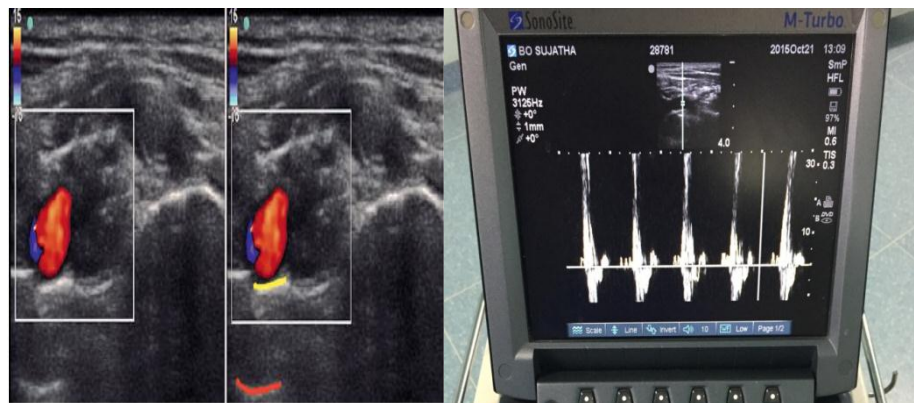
Doppler for identification of vessels. Indicated for both initial identification of subclavian vessels and aberrant vessels traversing the plexus before choosing the needle trajectory.
